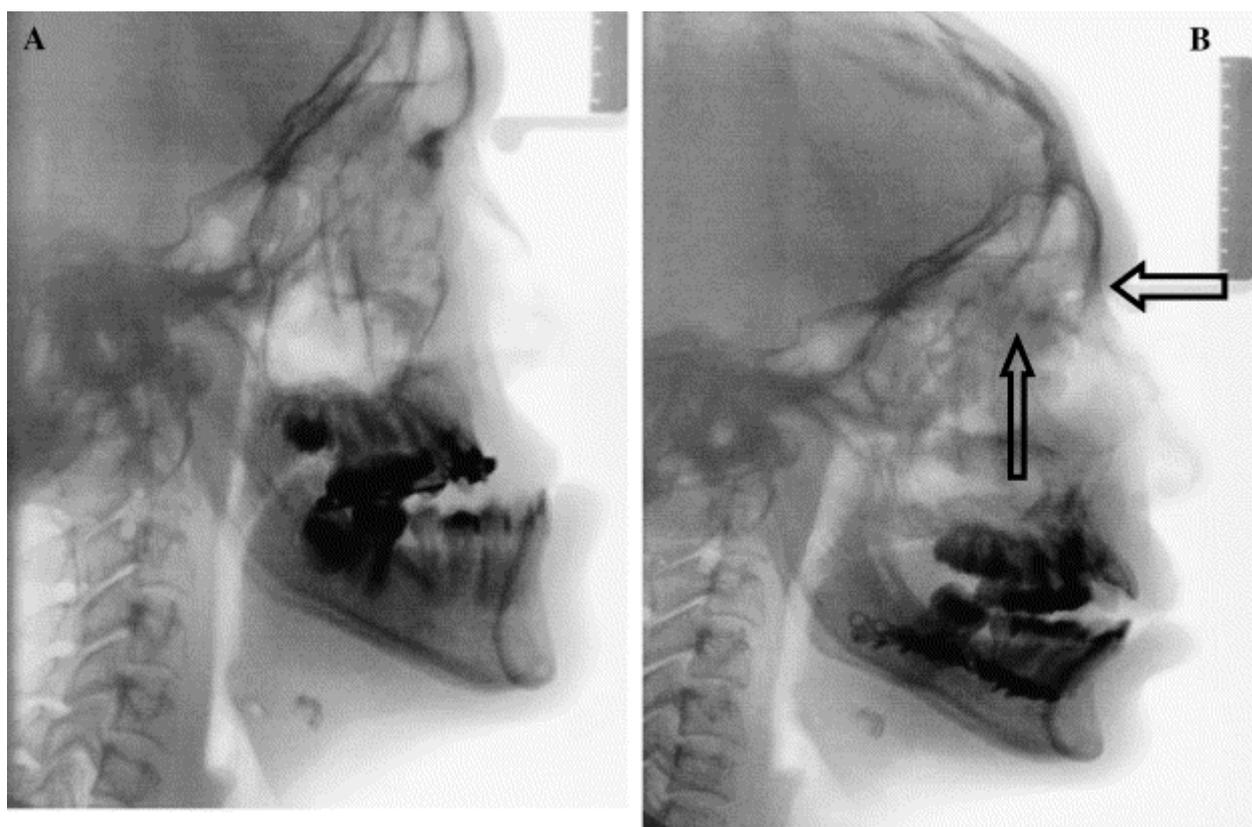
Pre- (A) and postoperative (B) radiographs of patient 1, indicating the Le Fort III movement after the Le Fort I osteodistraction. Arrows in B show demineralization of frontonasal and frontozygomatic sutures.
